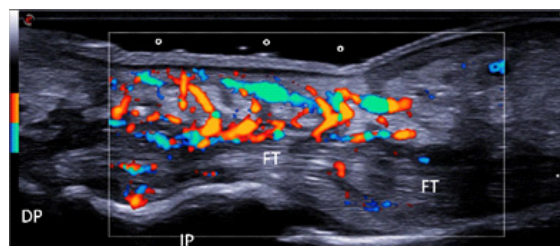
Power Doppler technology.
